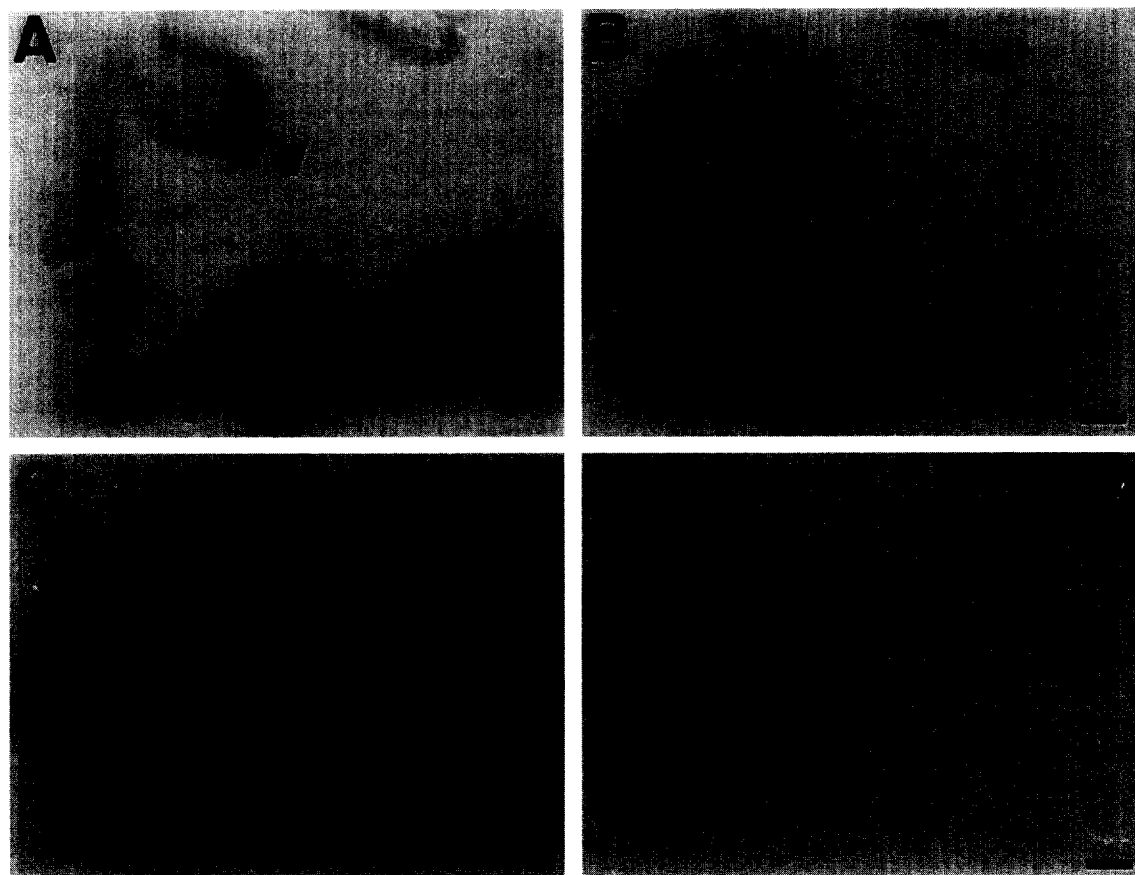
Representative autoradiographic images of [ $^3\text{H}$ ]sumatriptan binding to frontal cortex (A, B) and posterior striatum (C, D) sections. A, C: total binding. B, D: non-specific binding in the presence of 5-CT. Notice the high level of binding in globus pallidus and the moderate binding in putamen (image C), as well as the complete displacement of the total binding by 5-CT in posterior striatum (image D). Also notice the significant levels of [ $^3\text{H}$ ]sumatriptan binding sites in frontal cortex (image A) and the incomplete displacement of the total binding with 5-CT (image B) when compared with 5-HT (not shown). GP = globus pallidus; P = putamen; I–IV = layers I–IV of the frontal cortex; V = layer V of the frontal cortex. Bars = 2 mm.
